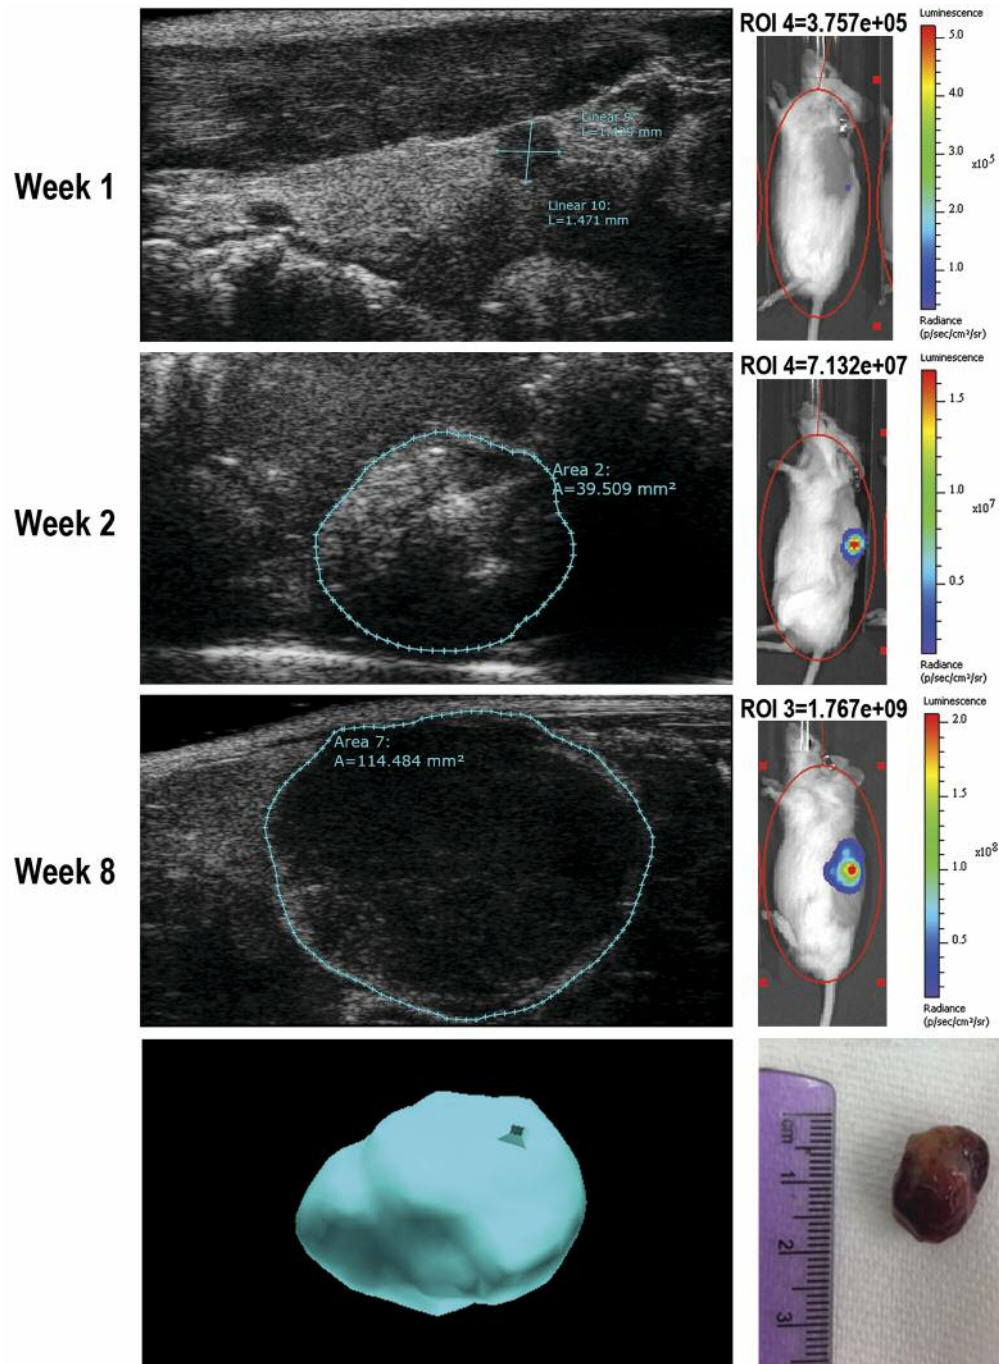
Ultrasound imaging was also utilized to monitor in vivo tumor growth for neuroblastoma (NB) orthotopic adrenal xenografts. Representative ultrasound and corresponding bioluminescence images at weeks one, two, and eight are shown. Evidence of engraftment was detected by week one in both imaging modalities. Tumor area (mm²) was monitored and increased with each time point from baseline. 3D ultrasound images (bottom panel) recapitulated physical characteristics of excised tumors at necropsy.
